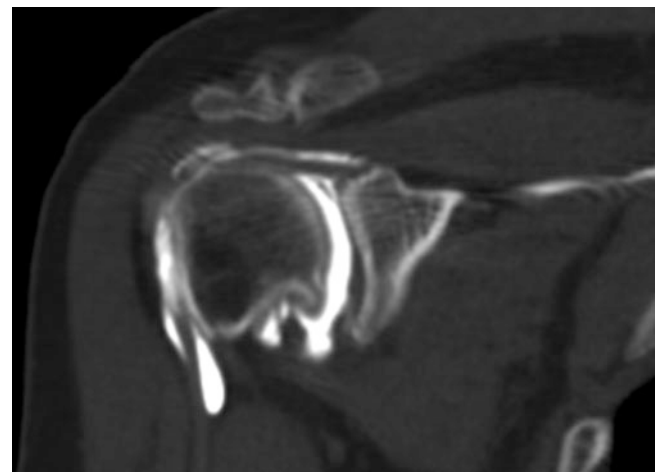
Coronal CT arthrogram showing partial-thickness articular surface tear of supraspinatus tendon in a patient affected by glenohumeral arthritis. The deep fibers of the tendon are interrupted, but not retracted, and this explains the linear (contrast-white) appearance of the tear. This lesion communicates with the joint. Tears of bursal surface of the supraspinatus tendon cannot be examined at arthro-CT, which permits opacification only of the joint surface
